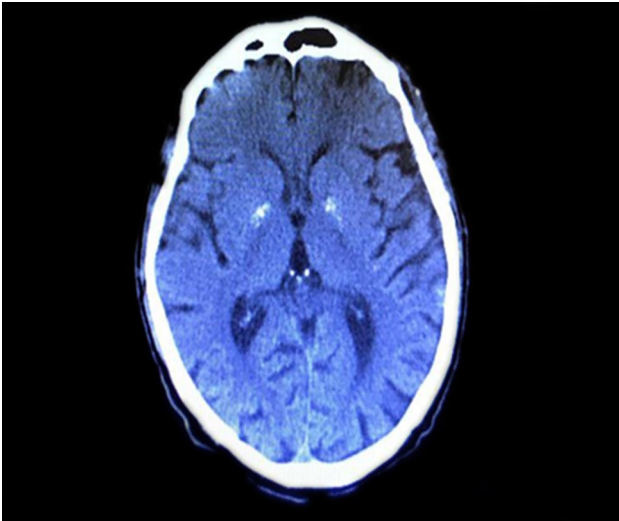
Unenhanced cranial computed tomography showed no hemorrhage.
